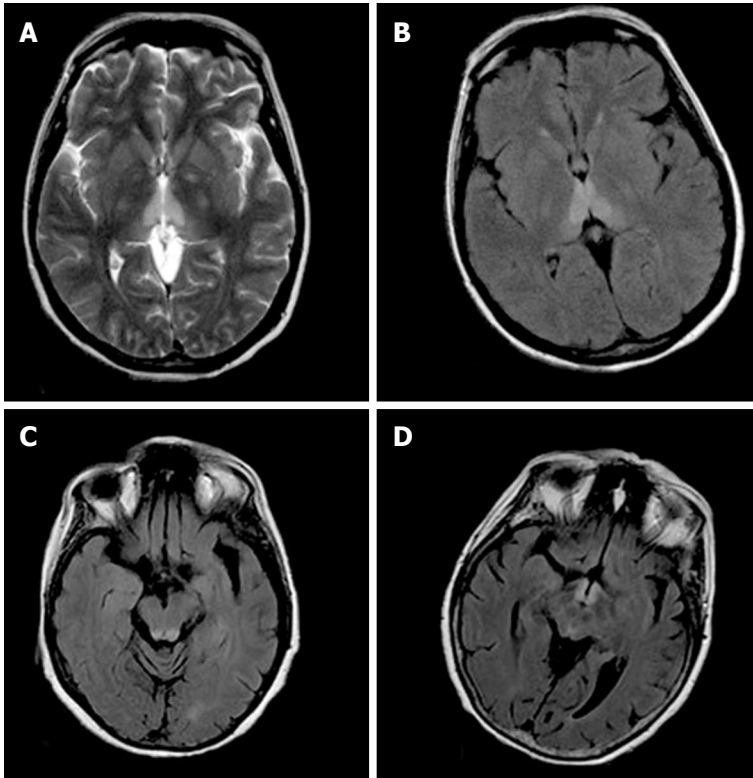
Magnetic resonance images in a patient with alcoholic Wernicke's encephalopathy. A: Axial T2-weighted image shows symmetrical high signal intensity lesions in the medial thalami; B: Axial fluid-attenuated inversion recovery (FLAIR) image shows symmetrical high signal intensity lesions in the medial thalami; C: Axial FLAIR image shows symmetrical high signal intensity lesions in the periaqueductal area; D: Axial FLAIR image shows symmetrical high signal intensity lesions around the mammillary bodies.
